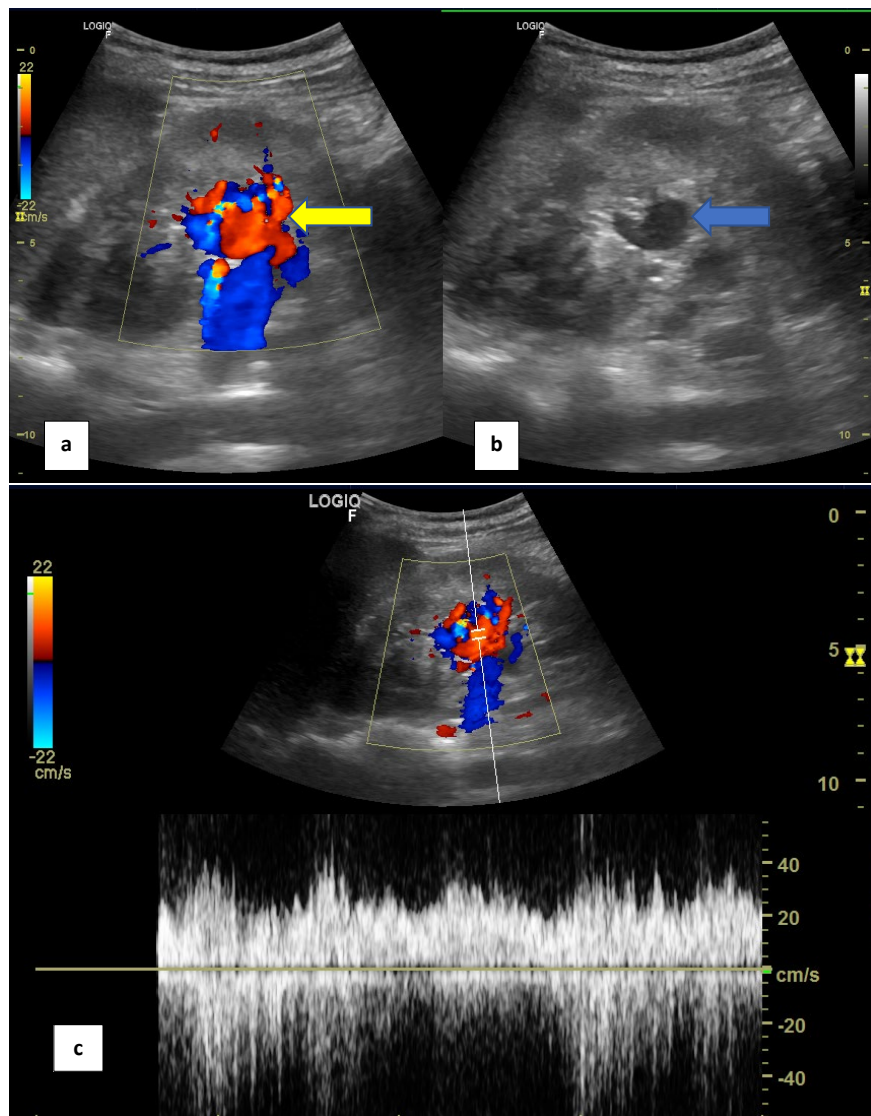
a,b) Doppler evaluation and B mode scan showing an anechoic lobulated structure (blue arrow) located in the middle section of the left renal pelvic region with colour flow on doppler evaluation (yellow arrow) and c) lesion demonstrating abnormal high-flow vascularity suggesting the presence of an AVM.
